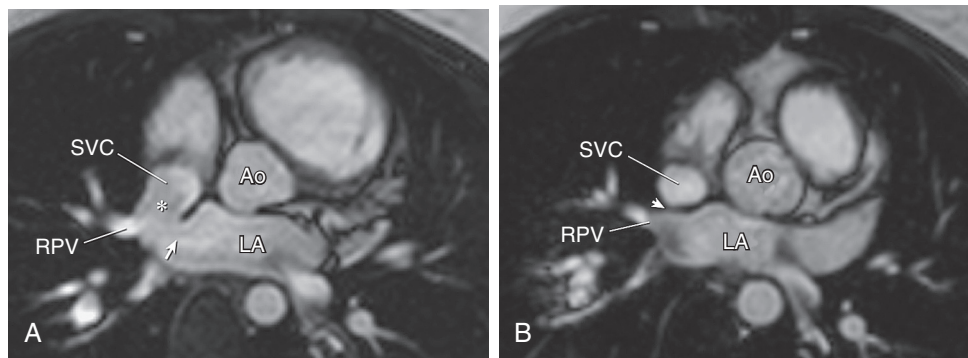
■ Previously healthy 33-year-old woman with increasing shortness of breath with exertion. A, Cine magnetic resonance image in the axial plane demonstrates a sinus venosus defect (*) in the wall that separates the superior vena cava (SVC) and the right upper pulmonary vein (RPV). The arrow indicates the orifice of the RPV through which blood can flow between the left atrium (LA) and the SVC. B, Repeat imaging in the same patient performed 1 year after surgery confirms closure of the sinus venosus defect (arrow). Ao, Aorta.
